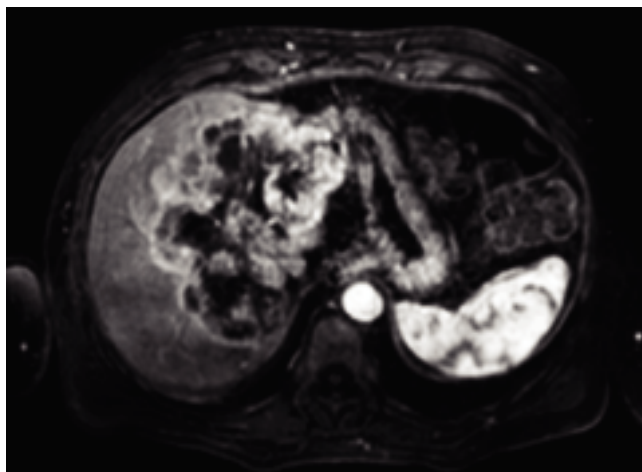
Contrast-enhanced MRI of the liver showing the intrahepatic cholangiocarcinoma (before treatment).
